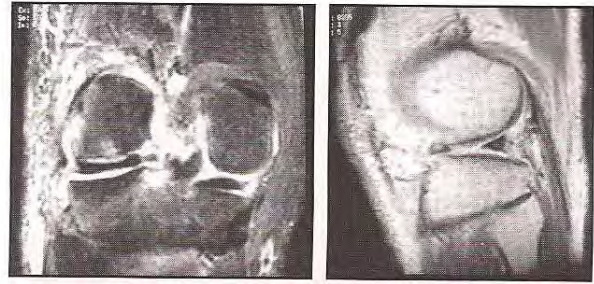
Lateral meniscus allograft transplantation in a young sportsman having undergone two prior lateral meniscus resection surgeries. On follow-up MRI note union and revascularization of meniscal margins with no evidence of graft shrinkage.
